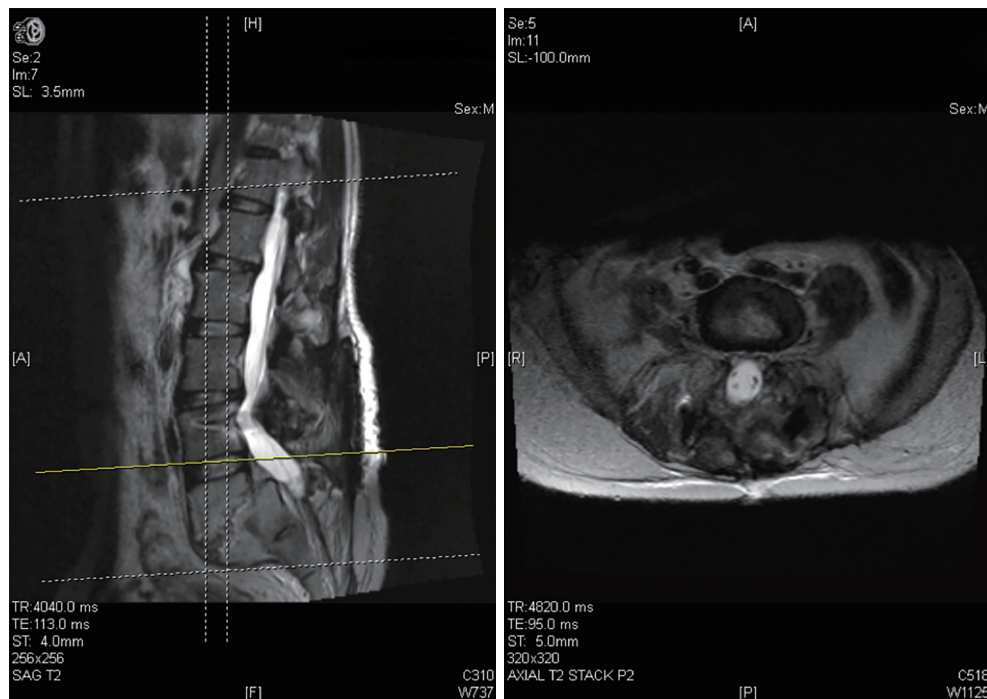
Repeat T2-weighted MRI imaging of lumbar spine (L4-5) at 15 months post-operation. MRI, magnetic resonance imaging; TR, repetition time; TE, echo time.
